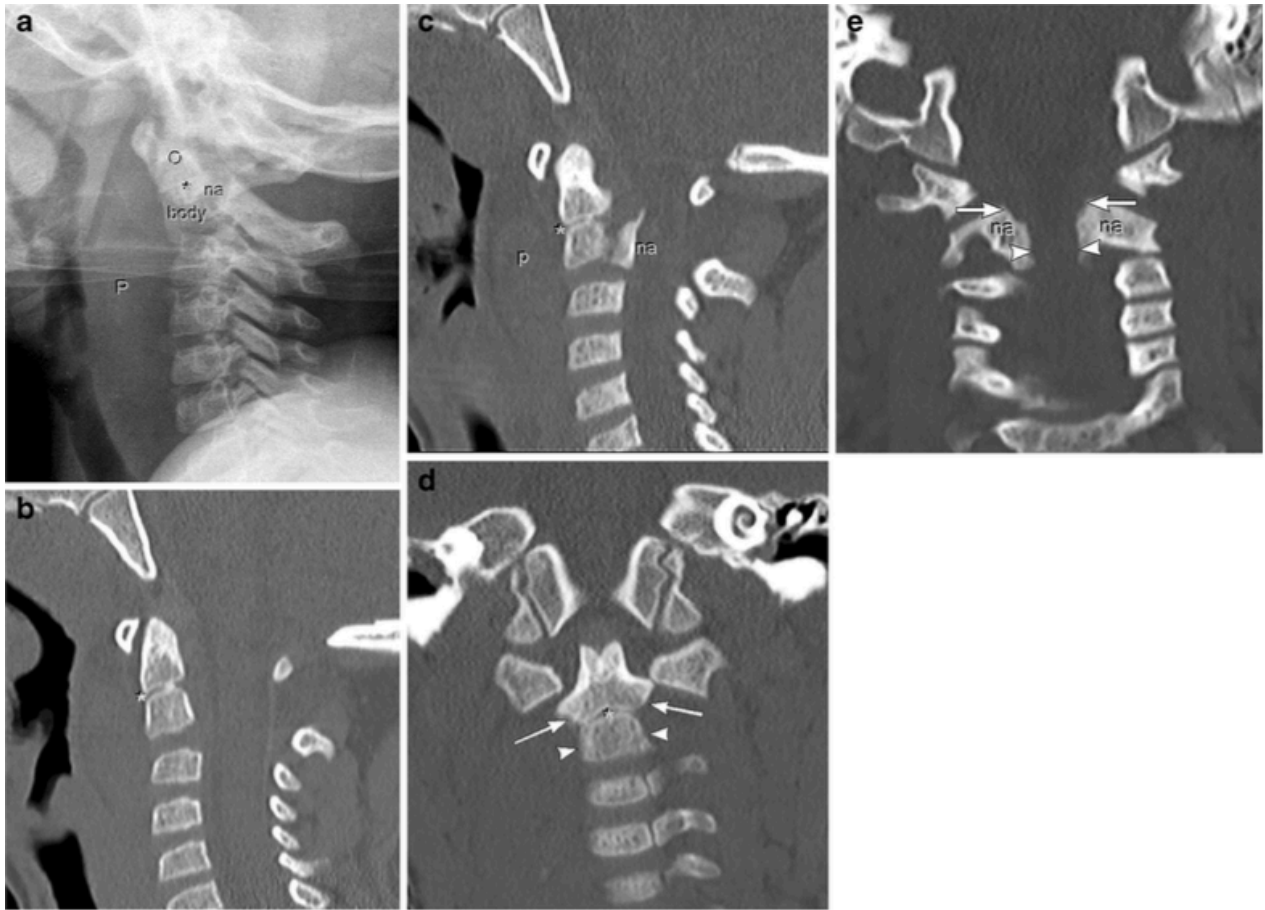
Type III subtype b fracture in patient 5, a 4-year-old boy who was struck by a motor vehicle while walking. (a) Lateral radiograph, (b) midline sagittal CT, (c) right parasagittal CT, and (d, e) coronal CT reformations images show fractures through the bilateral odontoneural (arrows) and bilateral neurocentral synchondroses (arrowheads) with anterior displacement and anterior angulation of the odontoid (o). The neural arches (na) are in normal position. This results in a twin towers sign with each neural arch representing one of the towers with nothing between (e). The odontocentral synchondrosis (*) is intact. There is marked pre-vertebral edema (p). This boy also had a non-displaced scapula fracture. The C2 fracture was treated via primary halo stabilization.
